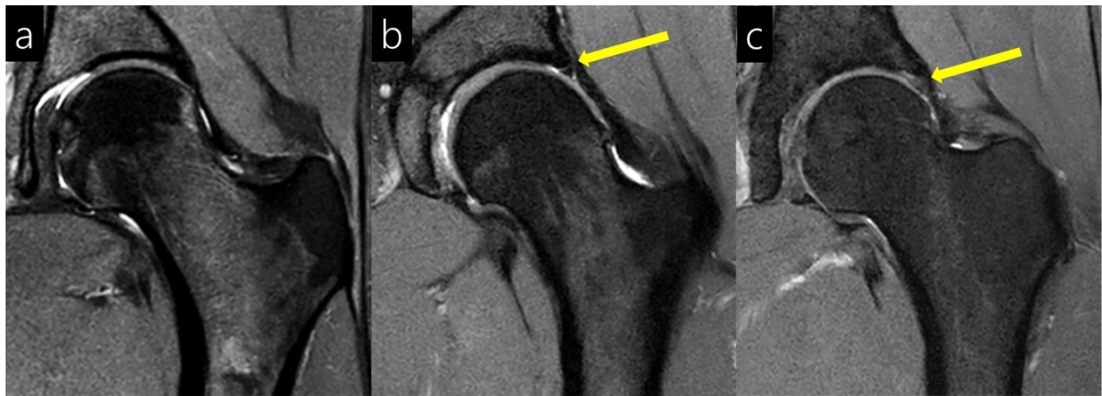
Labral conditions on unenhanced MRI.
